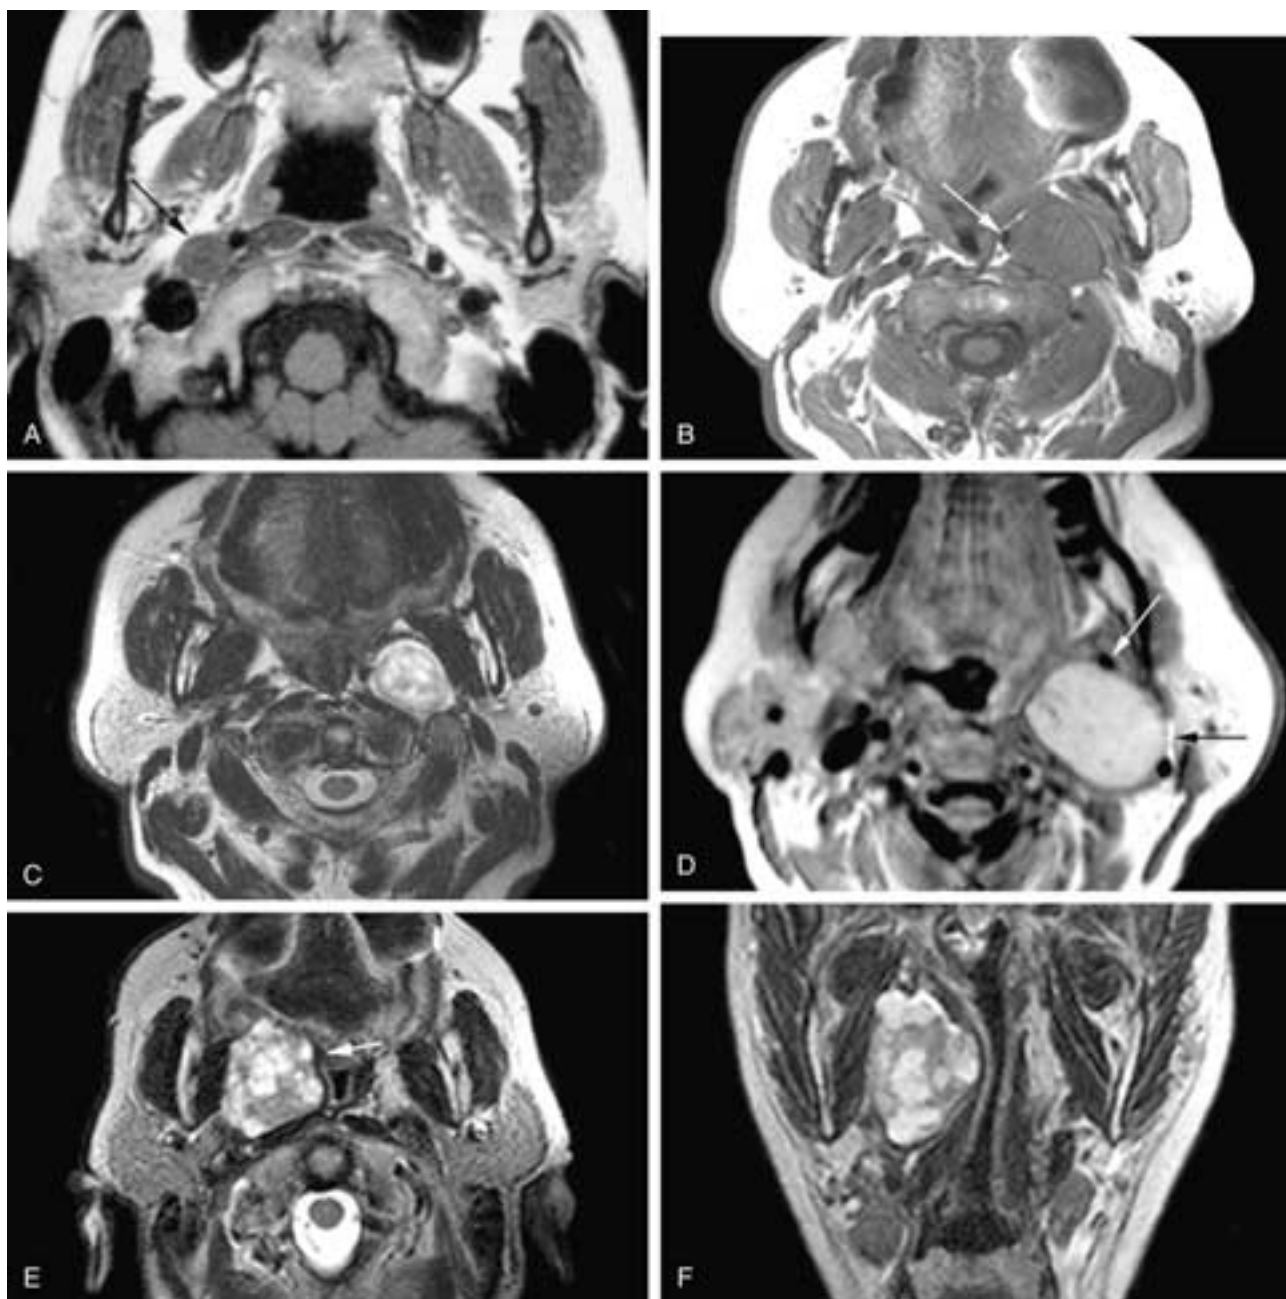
Axial T1-weighted MR image (A) shows a small ovoid mass (*arrow*) in the right carotid sheath (retrostyloid compartment of the parapharyngeal space) that pushes the ICA anteromedially and the internal jugular vein posterolaterally. This was a schwannoma of the vagus nerve. Axial T1-weighted (B) and T2-weighted (C) MR images show an ovoid mass in the left parapharyngeal space displacing the ICA anteromedially (*arrow* in B). This vagal schwannoma has a fairly homogeneous low T1-weighted signal intensity and a nonhomogeneous T2-weighted signal intensity. Axial T1-weighted MR image (D) shows a left parapharyngeal space mass that displaces the ICA anterolaterally (*white arrow*). This vagal schwannoma is separated from the parotid gland by a thin fat plane (*black arrow*). Axial (E) and coronal (F) T2-weighted MR images show an ovoid, nonhomogeneous right parapharyngeal space vagal schwannoma that displaces the ICA (*arrow* in E) anteromedially.
